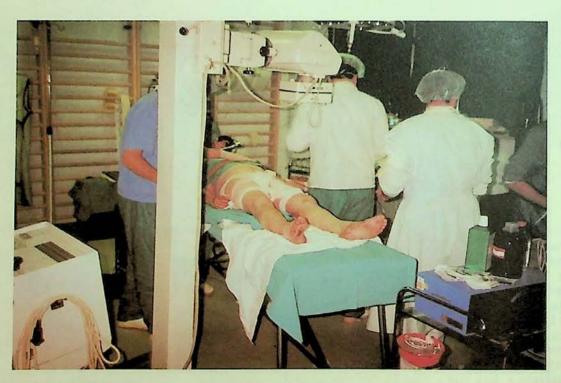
Mobile X-ray apparatus in the Surgical Theater.
